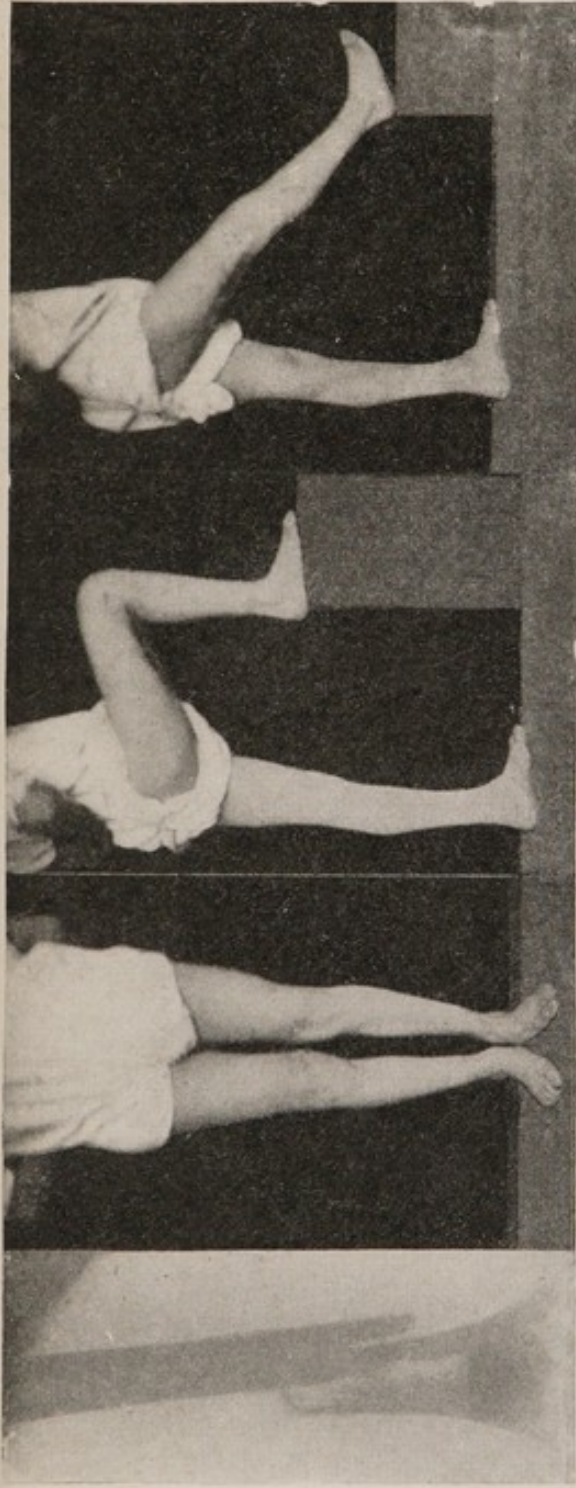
Lower-third fracture (right); radiograph taken on admission five weeks after being wounded; photographed four months after wound. Calliper extension. No shortening. Note flexibility and muscular condition. [Case E 140.]
